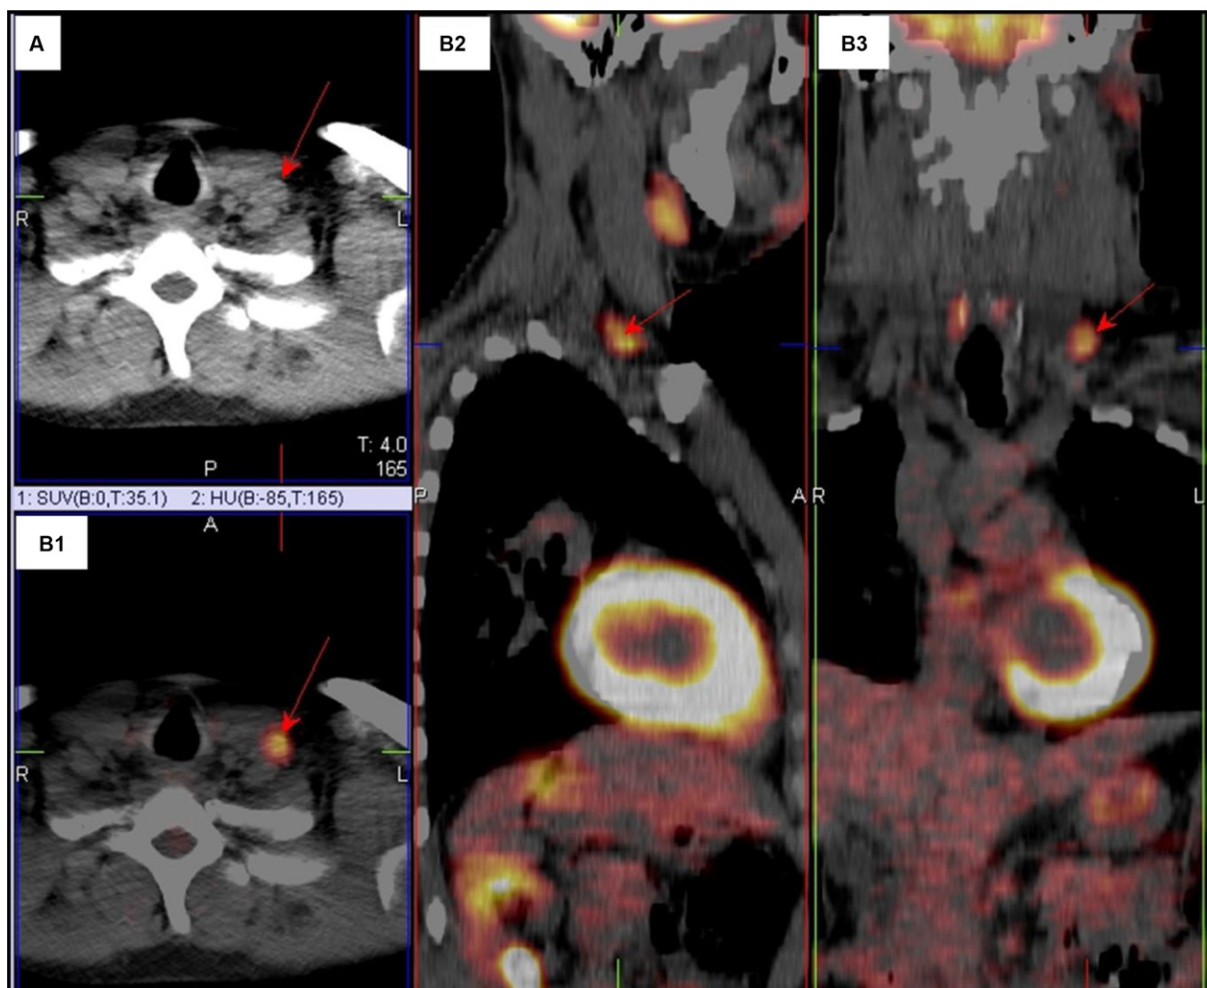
Axial CT (A) and ^{18}F -FDG PET/CT images in axial (B1), sagittal (B2) and coronal (B3) projection in a differentiated thyroid carcinoma patient with increasing serum thyroglobulin levels after thyroidectomy and negative radioiodine whole-body scan. PET/CT showed an area of focal increased radiopharmaceutical uptake corresponding to a left laterocervical lymph node (arrow) suspicious for tumor relapse (diagnosis confirmed by surgery).
